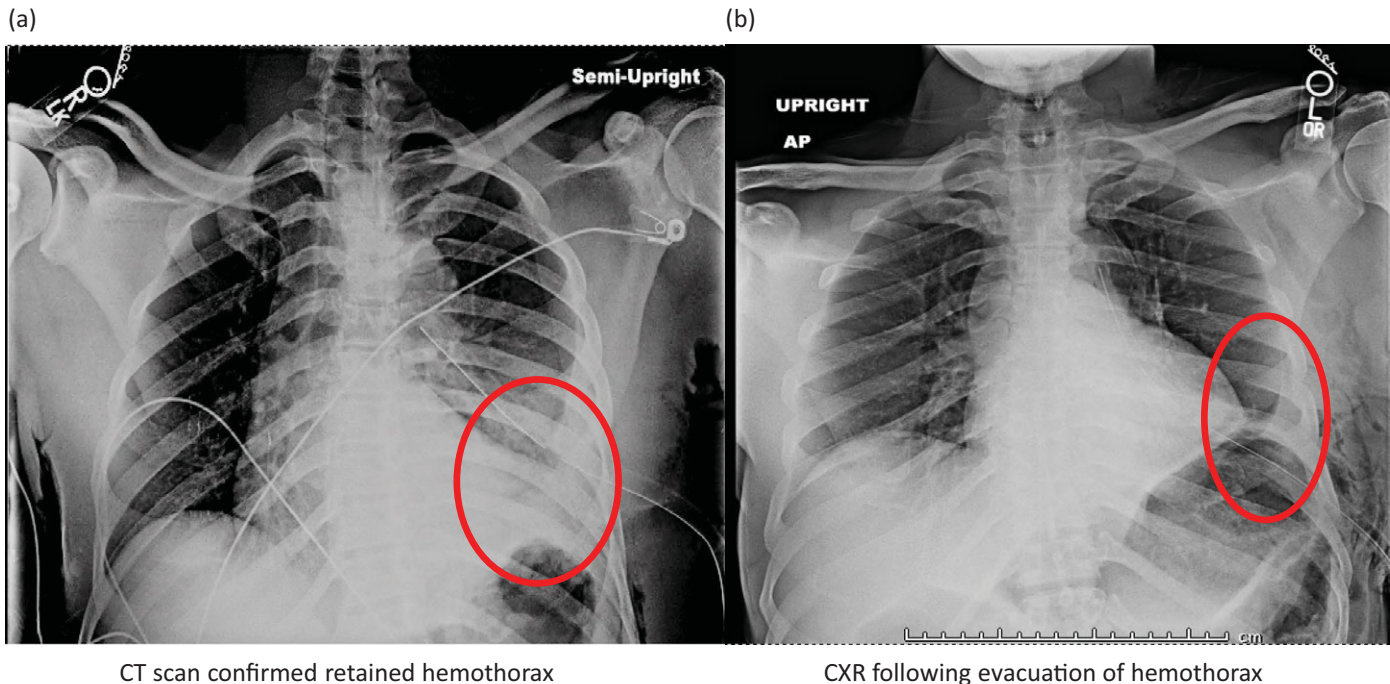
(a, b) Chest X-ray pre- and post-VATS evacuation of hemothorax.
